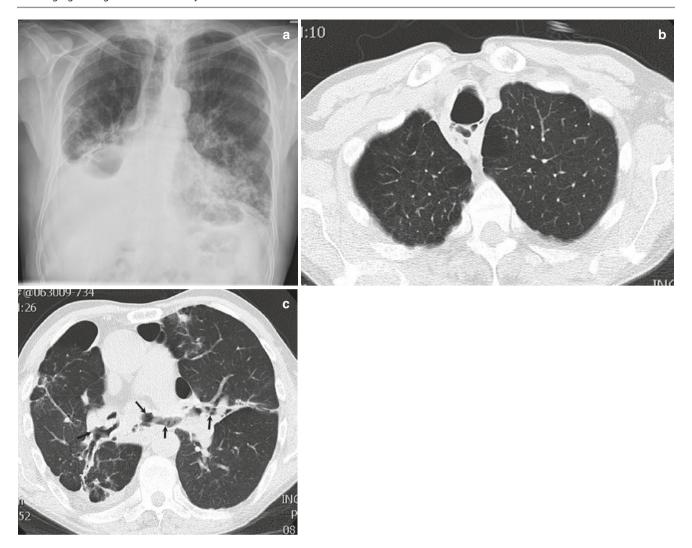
A 63-year-old man with Mounier-Kuhn syndrome. (a) Frontal radiograph shows dilated trachea and bronchiectasis with air-space opacities in lower zones along with right pleural effusion. (b, c) Axial
